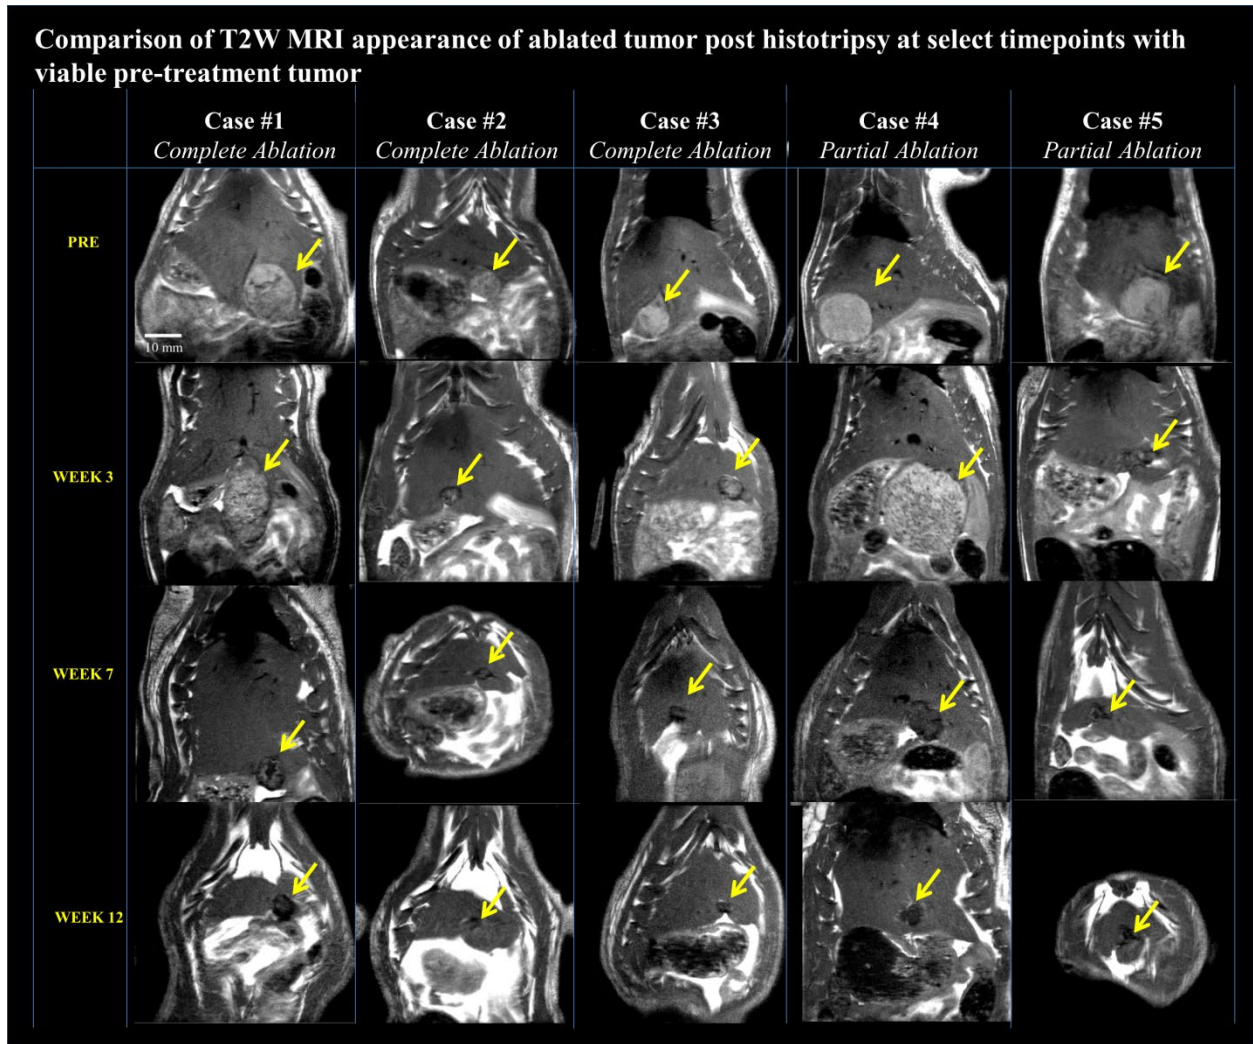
T2W MRI appearance of histotripsy treated tumor at select timepoints compared to pre-treatment viable tumor for complete and partial ablation cases. At week 3, the lesion begins to regress, resulting in T2 hypointense signal at the ablation site by week 7. The tumor continues to regress until week 12, but there is no further observable change in signal compared to week 7.
